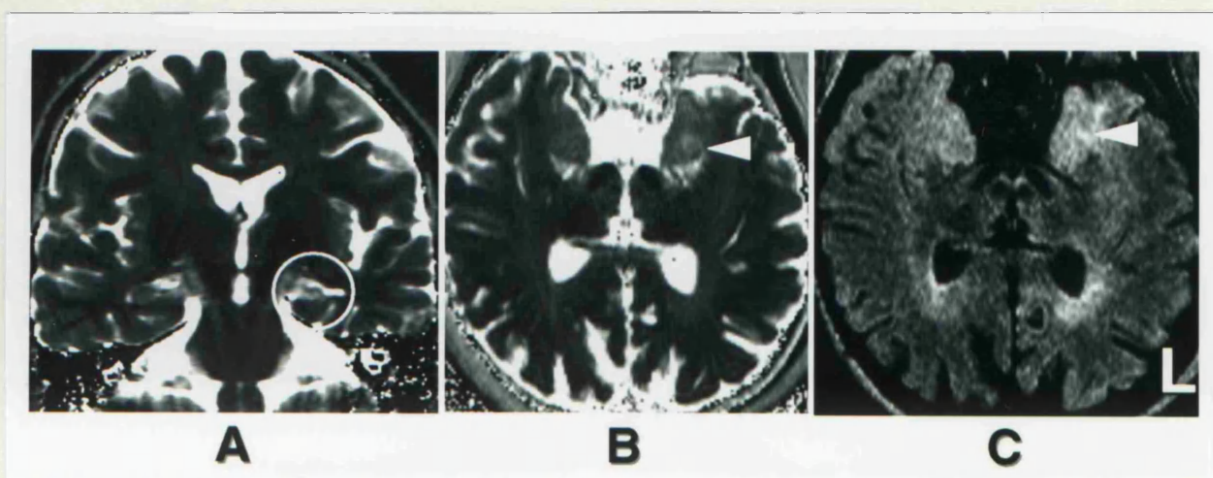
Amygdalohippocampal sclerosis. Patient was a 42 year old man with a history of prolonged FCs at the age of 2 years, and subsequent development of intractable TLE. He had an average of one CPS per week and had a total of around 40 SGS. Interictal EEGs showed a left temporal epileptic focus. MRI showed left HS. On the HCT2 map (A), the left hippocampus (in the white circle) was visibly atrophic and had an increased HCT2 signal. Hippocampal quantitation confirmed left HS: HCT2 right = 99 msec, HCT2 left = 125 msec (Normal (NI): ≤ 108 msec); HCVR (L/R) = 0.51 (NI: ≥ 0.87); HCV right = 4375 mm³, HCV left = 2245 mm³ (NI: ≥ 4348 mm³). AT2 signal on the left side (white arrow) was 109 msec and on the right 101 msec (NI: ≤ 104 msec). Notice that the hippocampus is not visible in the plane of the AT2 map. Therefore, the amygdalae can be evaluated independently of the hippocampi. The FLAIR image (C) confirmed that the high AT2 signal on the left (white arrow) was not due to partial volume effects with CSF, since CSF is black in this sequence. The high T2 signal was due to tissue changes, and in the context of HS on the same side most likely represented concomitant AS, i.e. amygdaloHS. [Hospital number: MVP20419].
